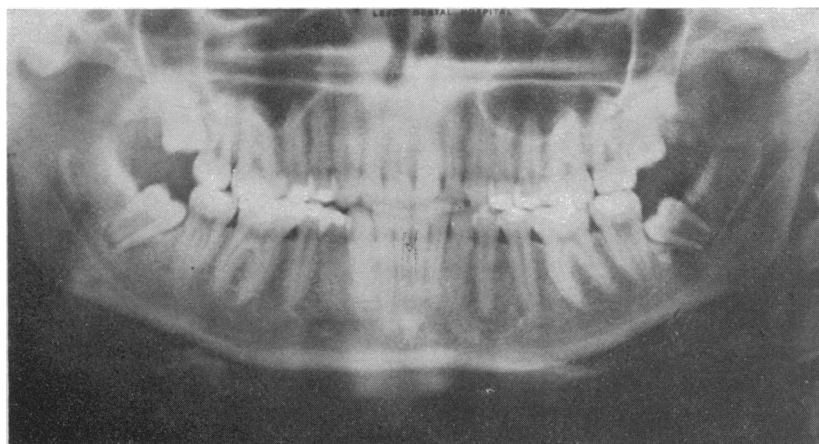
Orthopantomogram showing bilaterally impacted wisdom teeth.*
